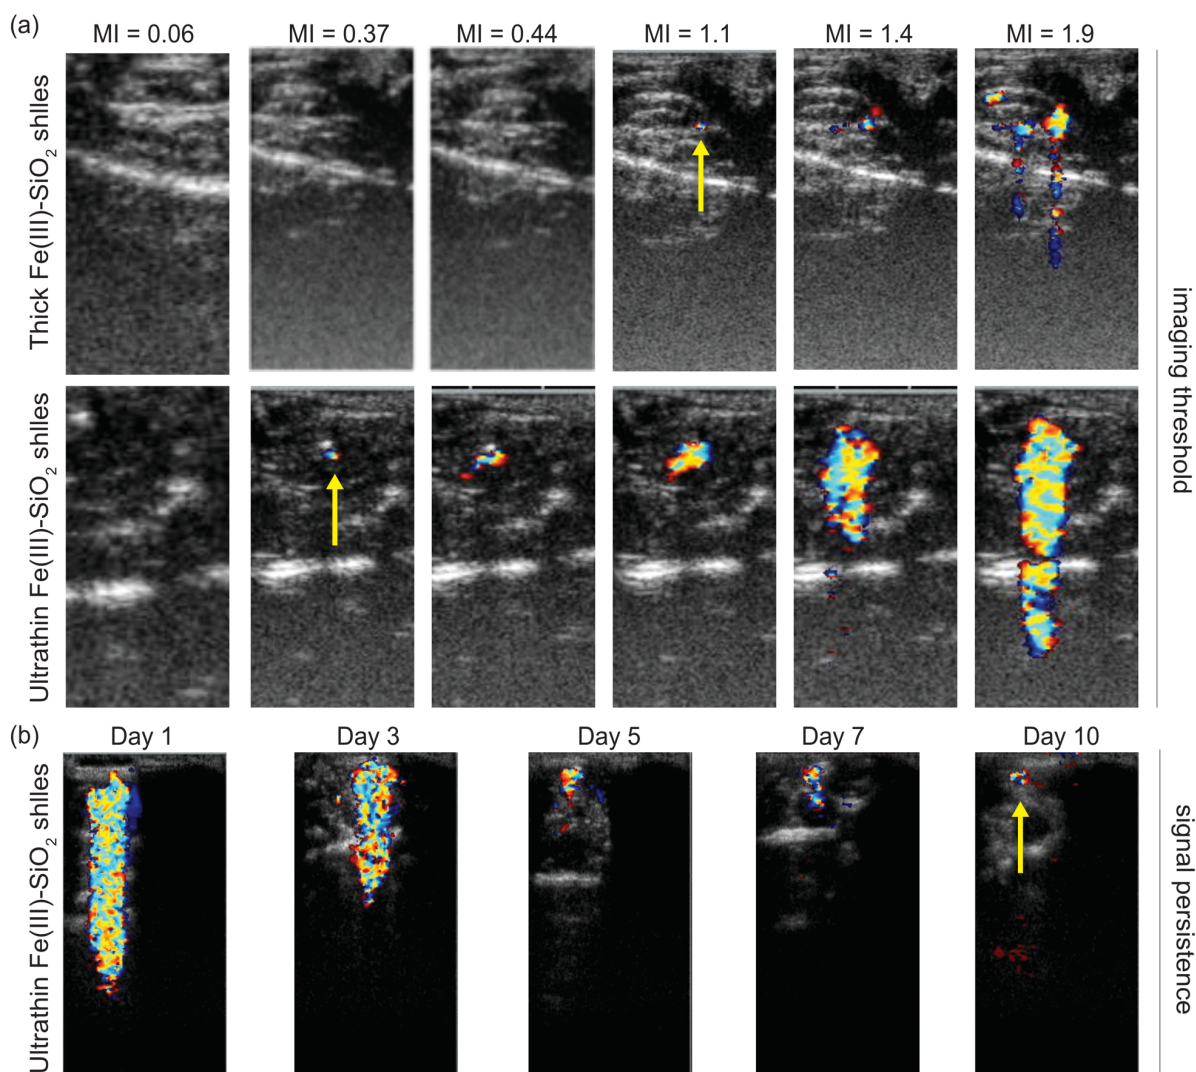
5: In vivo color Doppler ultrasound images of 2 μm Fe(III)-SiO₂ shells filled with PFP gas.
